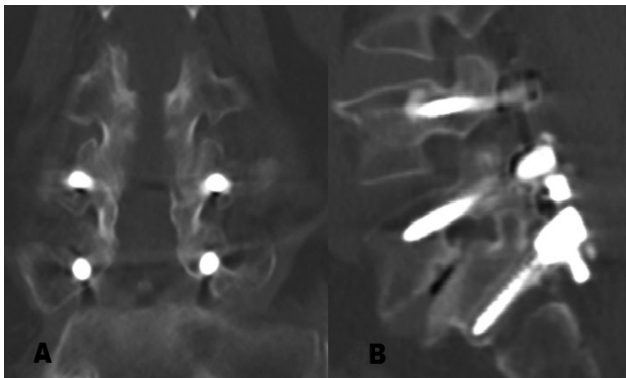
The expected fusion at coronal (A) and sagittal (B) 3D lumbar computed tomography view after 22 months later surgery
